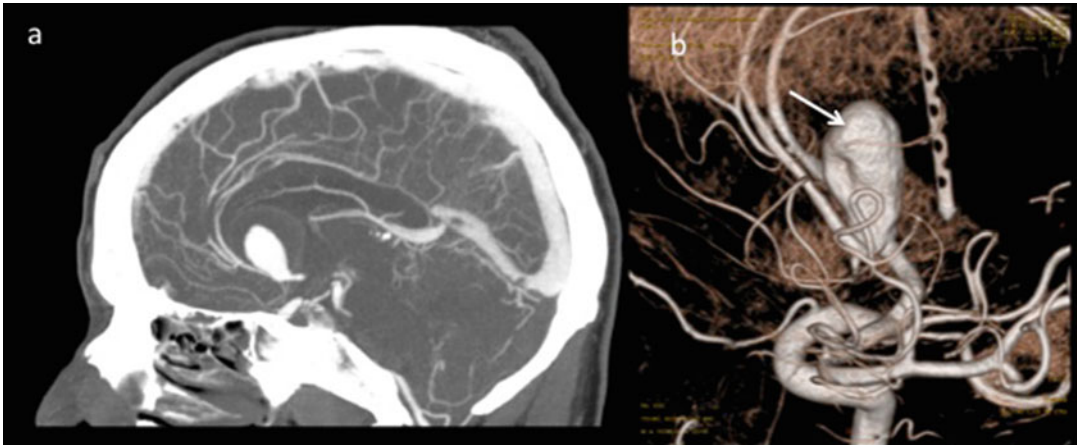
CT angiogram (a) and 3-dimensional reconstruction (b) showing a giant (2.5 × 2.7 cm) anterior communicating artery aneurysm (arrow). Peripheral thrombus
